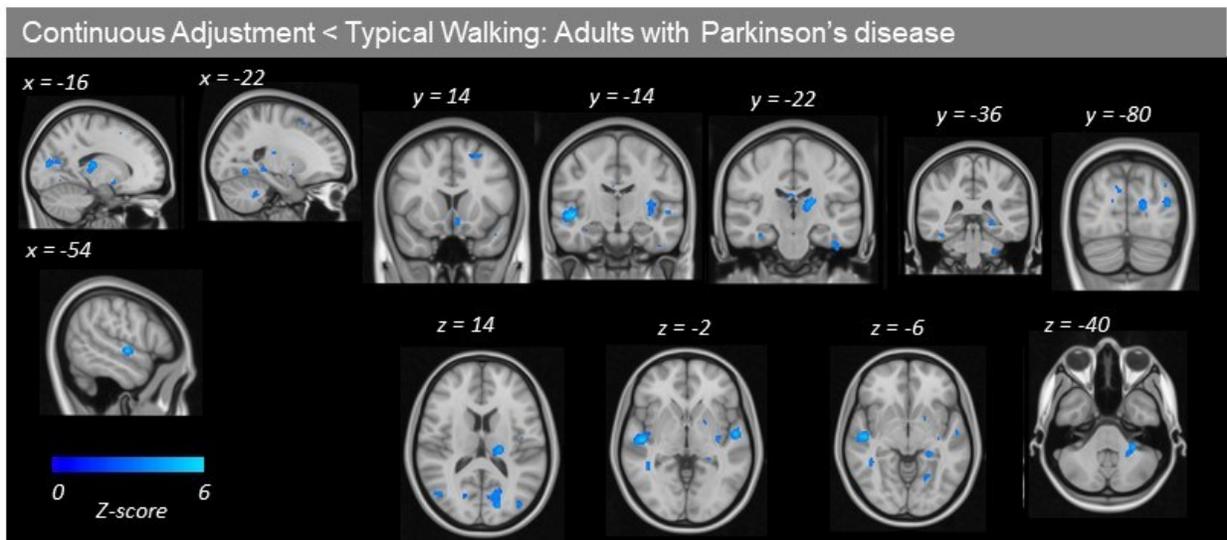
De-activation maps for decreased $[^{18}\text{F}]$ -FDG uptake during continuous adjustments (vs tied belt) in adults with Parkinson's disease. Compared to tied-belt, continuous adjustments
